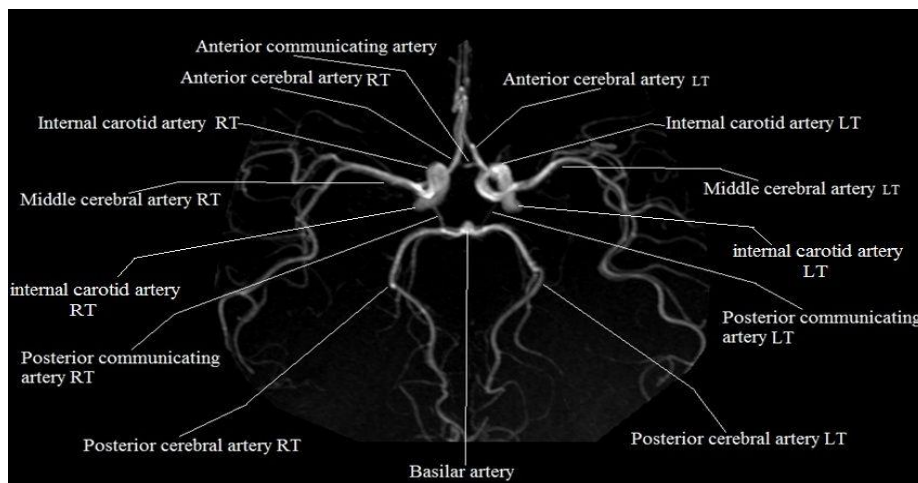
Normal anatomy of cerebral arteries on non-invasive CT angiogram
